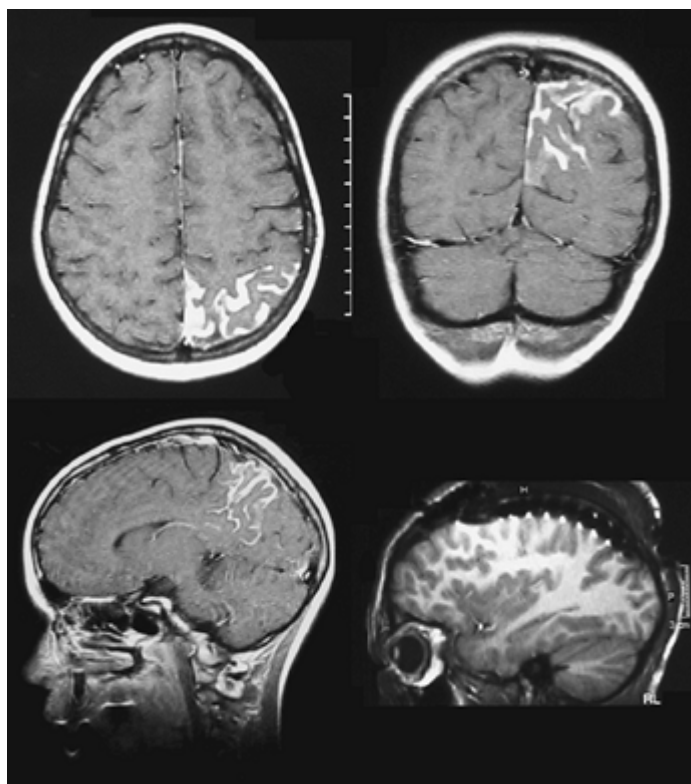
Multilobar resection for Sturge-Weber disease in a 10-year-old female. Axial (top left), coronal (top right), and sagittal (bottom left) magnetic resonance images demonstrate a left parieto-occipital lesion consistent with vascular malformation. Invasive diagnostic monitoring was performed with grid and strip electrodes (bottom right). Subsequently, a left parieto-occipital extended lesionectomy with multiple subpial transections was performed. Pathology demonstrated Sturge-Weber disease.
